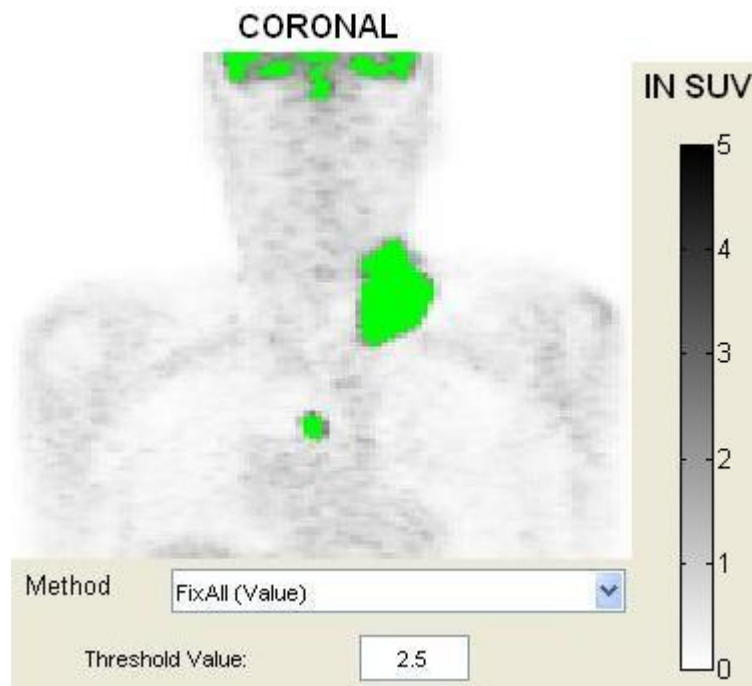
Visual Display of a Fixed 2.5 SUV Threshold Segmentation over an Image
